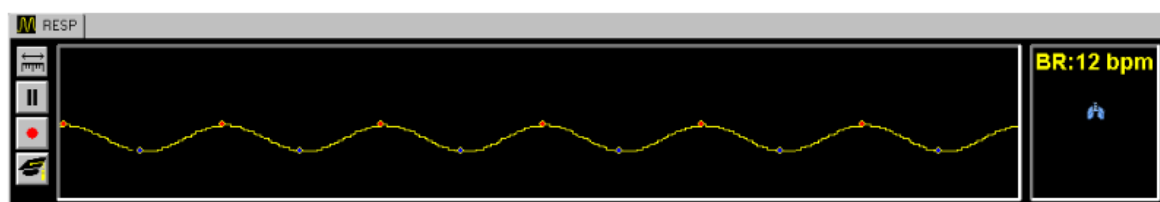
Registration of breathing cycle with means of a belt around the waist. The acquisition protocol of the ^{90}Y -PET/CT scan consists of 4 different subparts:
